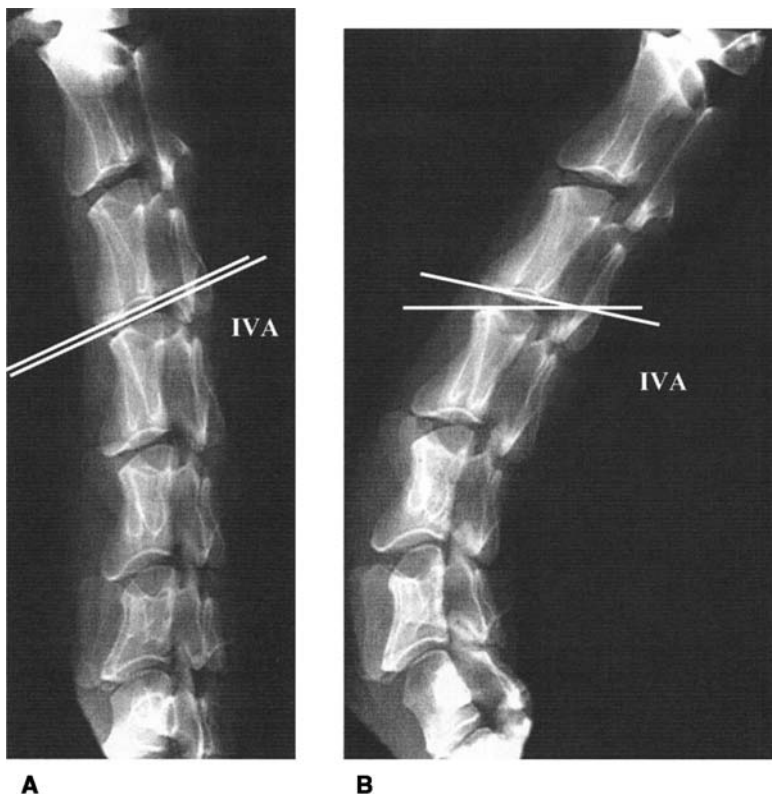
The motion segment C3-C4 was evaluated using lateral digital functional radiographic scans in (A) flexion and (B) extension. Flexion/extension differences of intervertebral angle (IVA) and lordosis angle were calculated.
